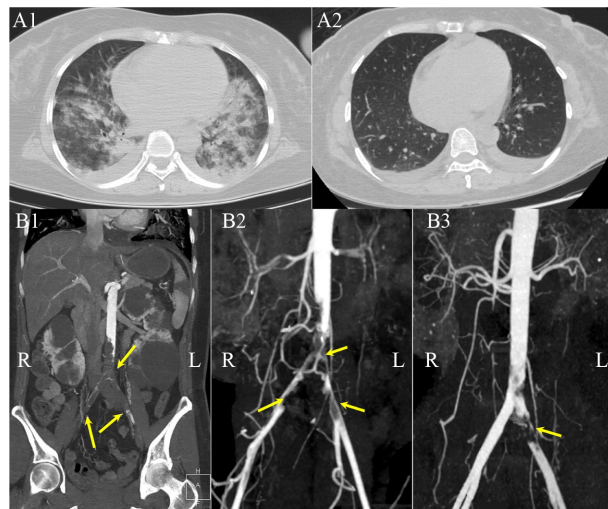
The enhanced CT of chest, abdomen, pelvis, and lower limbs. (A1) Diffuse lung infection with pulmonary edema and pleural effusion. (A2) Repeated CT demonstrated that the lung infection and pulmonary edema have improved significantly (day 7). (B1) Aortic occlusion due to aortic thrombosis in the infrarenal abdominal aorta, branch of the superior mesenteric artery, bilateral common iliac arteries, internal and external iliac arteries (arrows). (B2) Aortic thrombus was partially dissolved (day 4) (arrows). (B3) Aortic thrombus was further dissolved after intra-aortic recombinant tissue plasminogen activator (rt-PA) injection and subsequent thrombus aspiration via right femoral artery approach were performed (day 6) (arrow).
